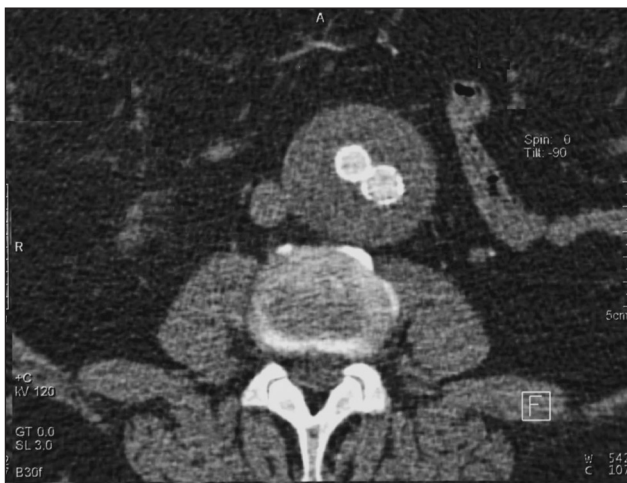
Computed tomography angiography at one month without evidence of endoleak
